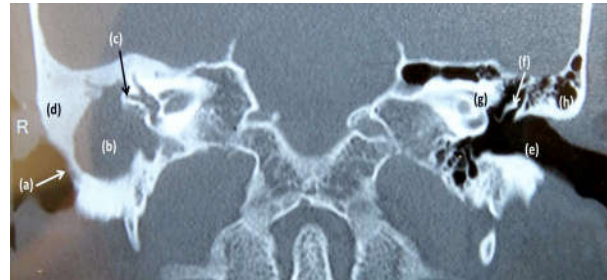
CT Scan in coronal section showing (a) Obstructed external auditory canal of right ear, (b) Cholesteatoma cavity, (c) Right lateral semicircular canal, (d) Fibrous dysplasia in right temporal bone, (e) Patent external auditory canal of left ear, (f) Incus, (g) Cochlea, (h) Normal air cells in temporal bone
